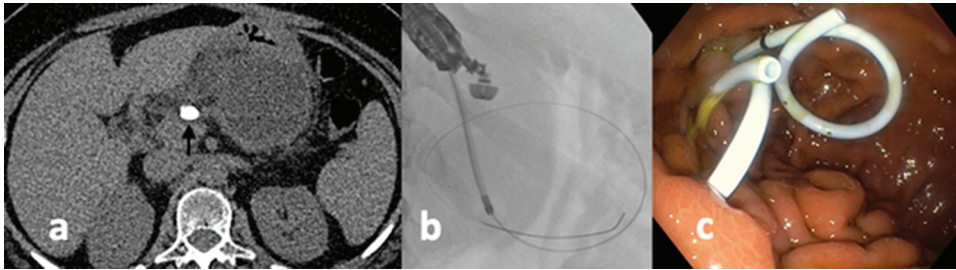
CT-Scan shows a pancreatic pseudocyst above an obstructive pancreatic stone (arrow); (a) EUS drainage of the pseudocyst (b) by insertion of double pigtailed plastic stents (c).
